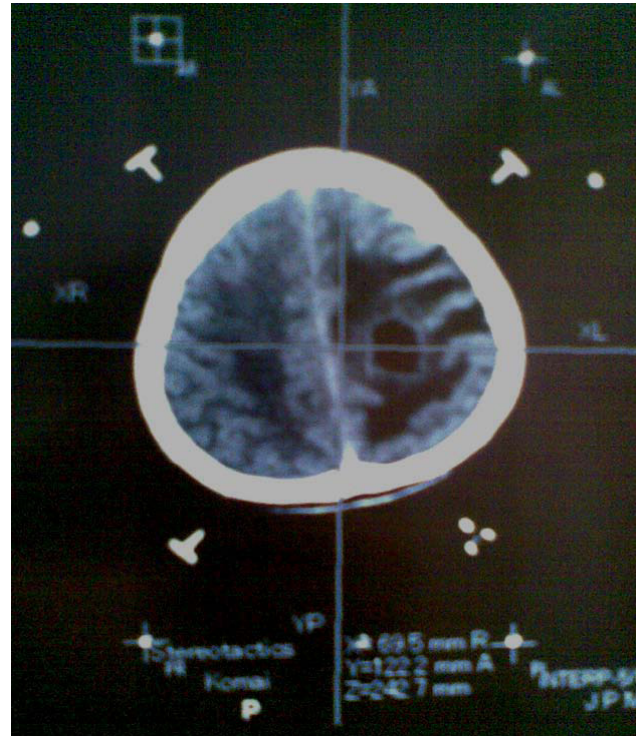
CT scan brain plain axial image (during procedure) of a 28 years old male patient, stereotactic aspiration performed, diagnosed pyogenic abscess.
